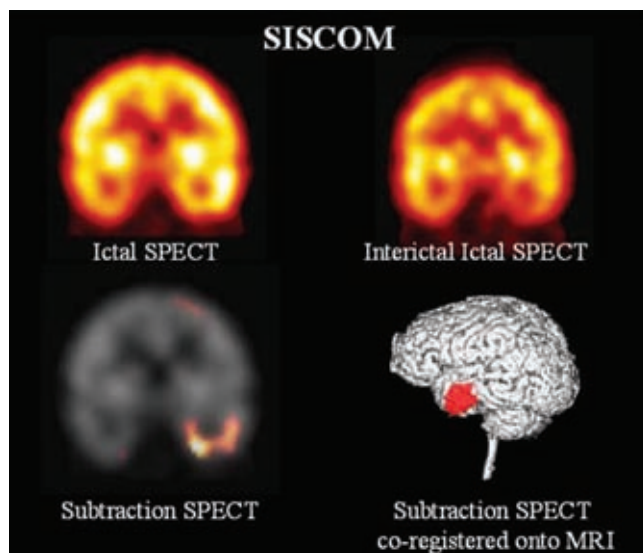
Ictal SPECT coregistered to MRI (SISCOM). SISCOM in a patient with right temporal lobe epilepsy. Routine MRI was normal. Note that the right side of the brain is on the right side of the figure
